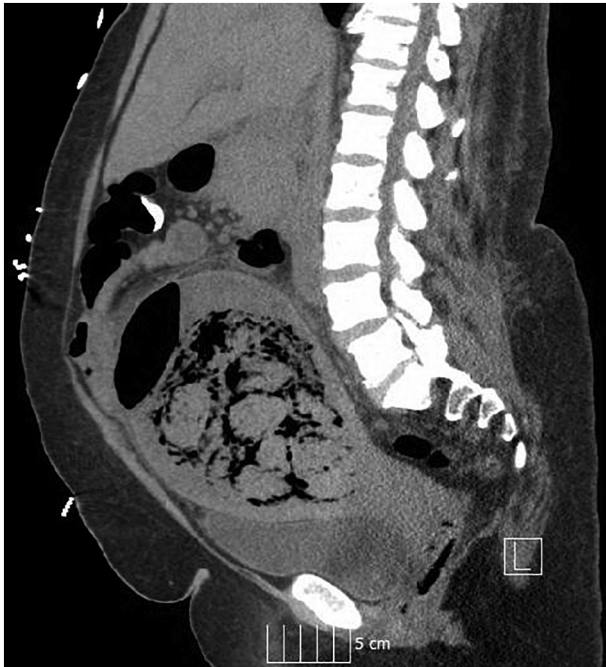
Sagittal computed tomography image with intra-venous contrast showing a distended uterus with multiple intra-cavitary masses spanning containing a large amount of gas with air-fluid level.
